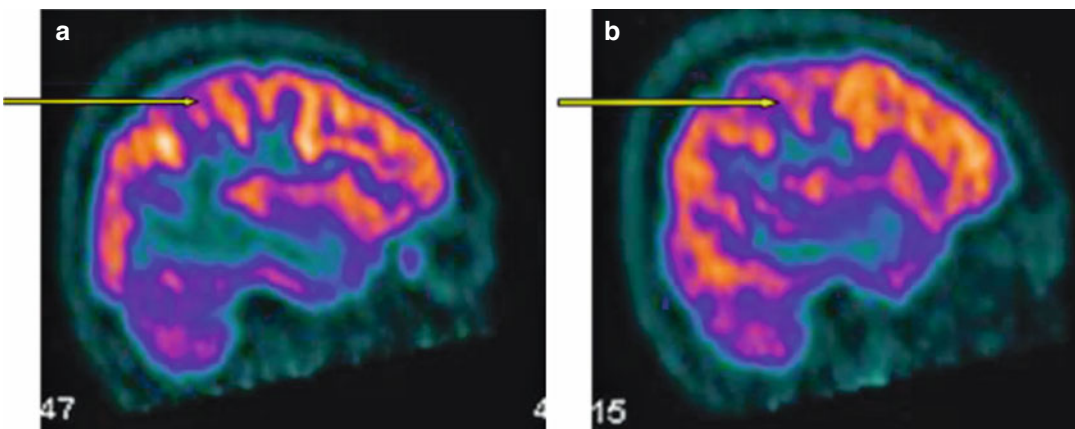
Brain sagittal PET/CT images in ALS patient. (a) Sagittal normal metabolic representation of right motor cortex (yellow raw). (b) Hypometabolic left motor cortex (yellow raw)
